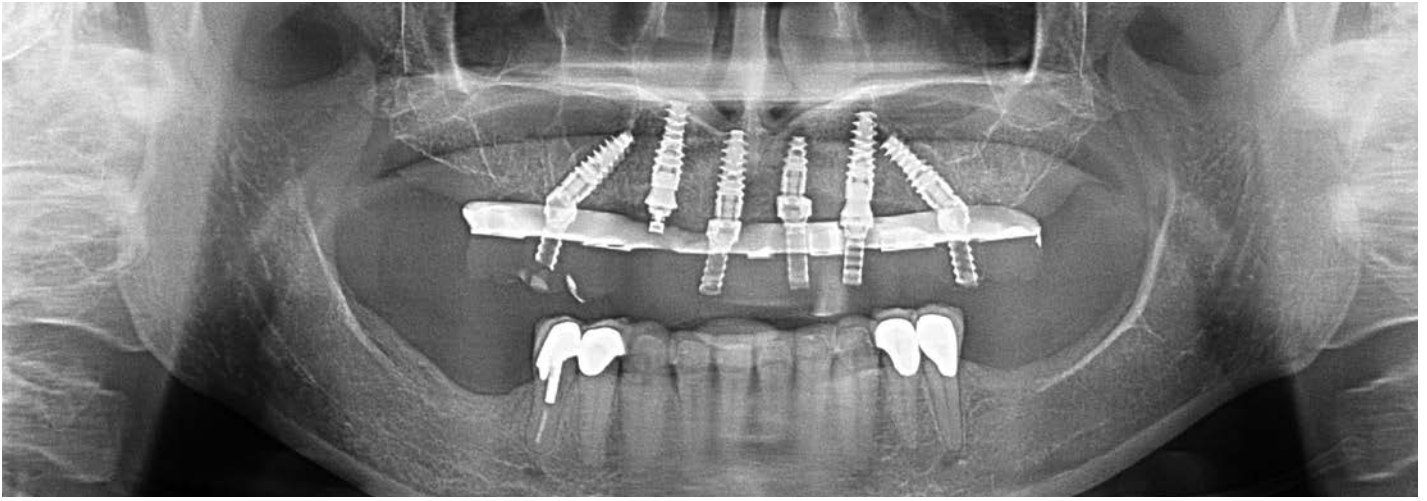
Radiographic confirmation of transitional prosthesis seating.
